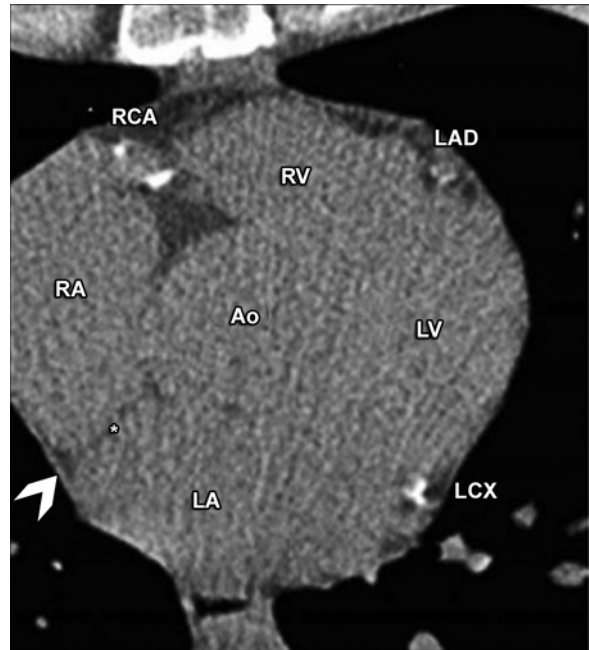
Considerable information on cardiac structures can be garnered from noncontrast CT. The left anterior descending (LAD), left circumflex (LCX), right coronary artery (RCA), and the ascending aorta (Ao) can be seen, as labeled. The four chambers of the heart are also seen and labeled as RA (right atrium), RV (right ventricular outflow tract), LA (left atrium), and LV (left ventricle). Relative chamber sizes can be estimated from noncontrast CT. The pericardium is visible as a thin line (arrowhead). The inter-atrial septum is also seen (asterisk)
